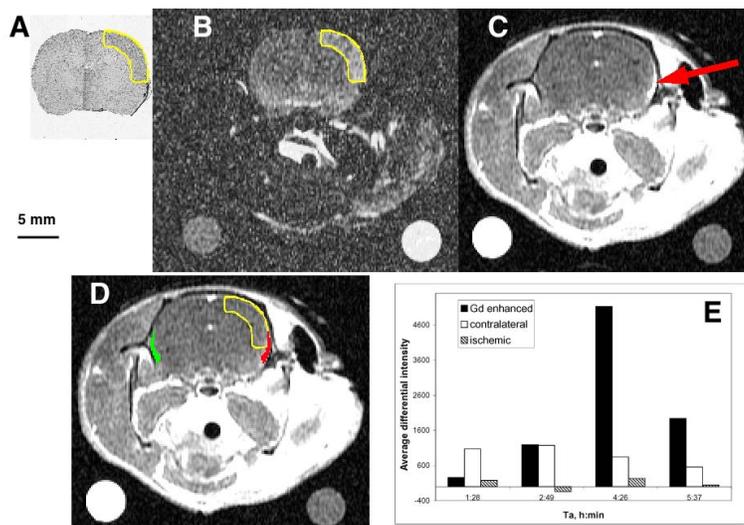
(A) The ischemic lesion ROI (outlined) identified using the surface reflectivity; (B) a perfect overlap of this ROI with the lesion visible on the DWI scan; (C) the appearance of Gd-DTPA in the CSF space on the ischemic side (arrow) but not on the contralateral side in the T1w image; (D) ROIs for the ischemic region (yellow), the CSF space with maximal enhancement of Gd-DTPA (red), and the contralateral CSF space (green); (E) a sharp rise of the Gd-induced signal enhancement in the ROIs shown in (D) for the ipsilateral CSF space (solid bars) and the ischemic cortex (hatched bars) compared with the homotopic contralateral CSF (white bars). T_a, time after occlusion.
